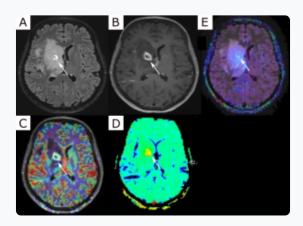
Contrast-enhanced Fluid Attenuated Inversion Recovery (FLAIR) (A) and contrast-enhanced T1W (B) showing central annular contrast enhancement and diffuse FLAIR hypersignal in the frontal lobe and basal ganglia. DSC PWI relative Cerebral Blood Volume (rBCV)(C) and permeability coefficient (D) showing both an elevation in their parameters, suggesting both TP and PTE, without ruling out TP. APT (E), showing mildly elevated signal, under the suggested thresholds(17), in favor of PTE.
